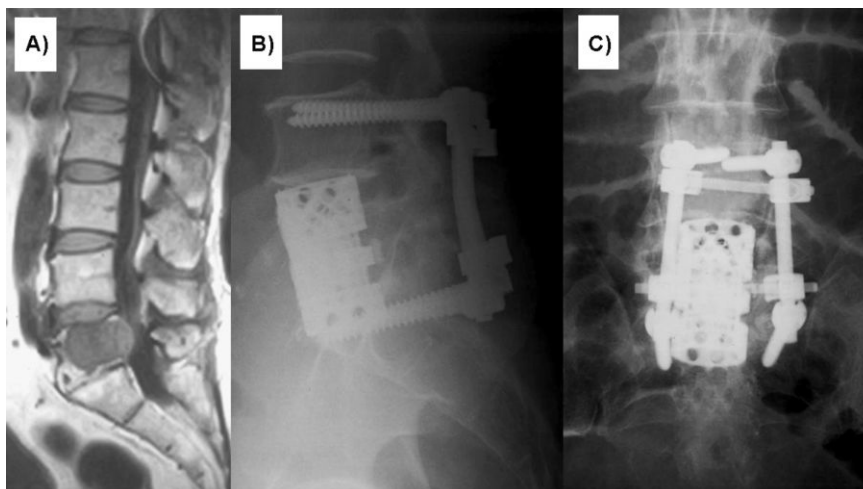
A 68-year-old male patient with a chordoma in his L5 vertebra (patient #5). A) Preoperative sagittal T1-weighted MR imaging of the patient; B) Lateral radiographic view after the operation; C) Antero-posterior radiographic view after the operation.
